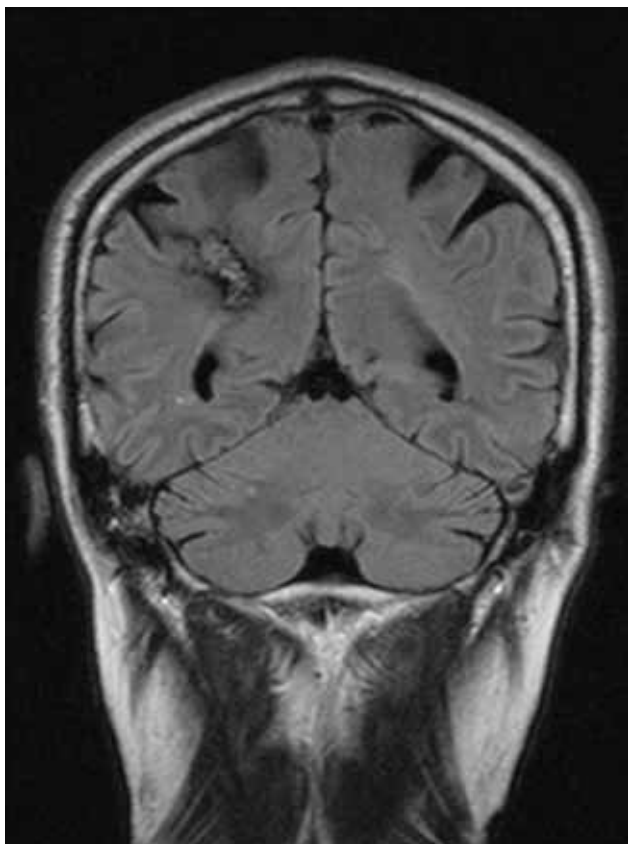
cor FLAIR – Subcortical ischemic lesions
